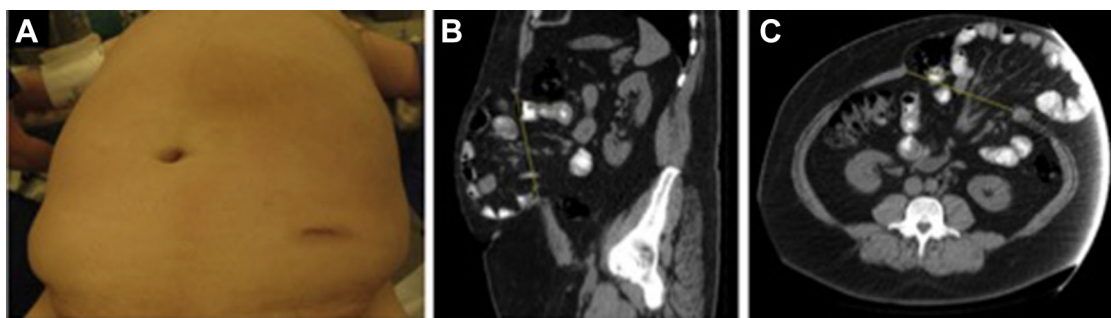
Complex ventral hernia with massive fascial defect. The study population included all patients with massive fascial defects that could not be reapproximated primarily after anterior components separation. A 50-y-old male patient with complex ventral hernia is presented as an example (A), with computed tomography images of his massive fascial defect presented as a sagittal (B) and transverse (C) sections. (Color version of figure is available online.)
